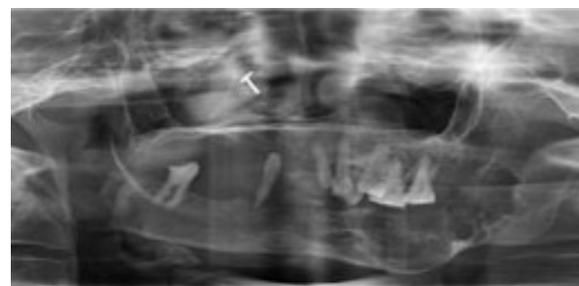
Orthopantomogram showing multilocular radiolucenices extending from symphysis to ramus region on left side.
